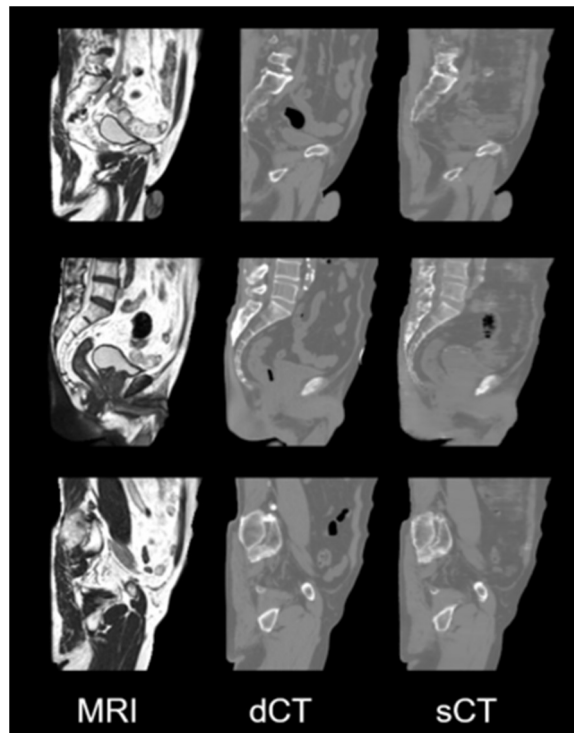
The representative sagittal slice views of MRI, dCT and sCT for pelvis
